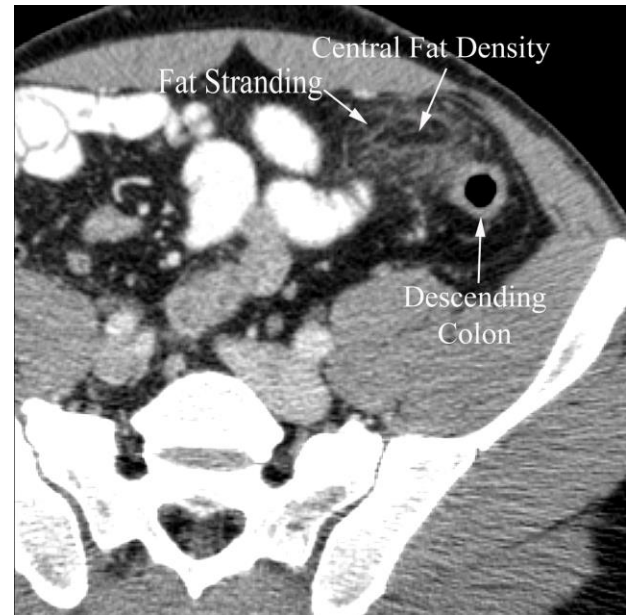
Appendagitis epiploicae in a 35 year old man with right lower quadrant pain. Axial CT performed with oral and intravenous contrast demonstrates soft tissue stranding in the pericolic fat along the descending colon with a central area of fatty density.
